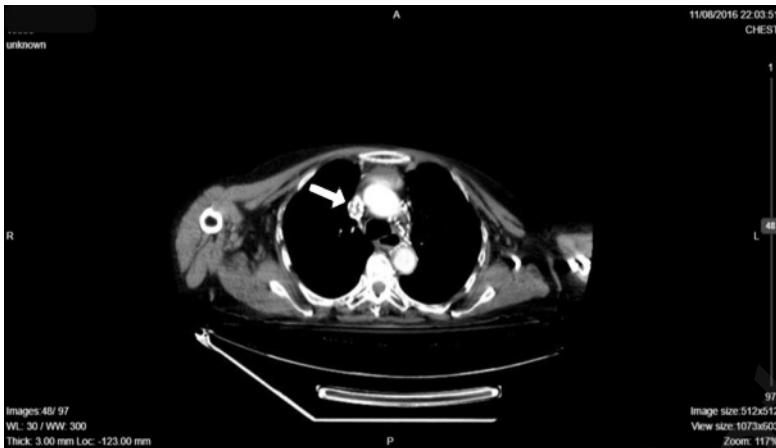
CT image of superior vena cava thrombosis.
